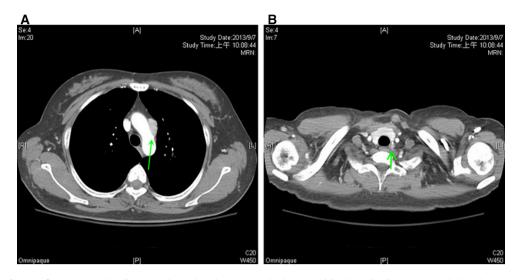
6 years after the first surgery, the CT scan showed patient No. 11 had one positive location in zone II and the other one at the left lower neck. a one positive location in Zone II. b the other positive location at *left lower neck*
